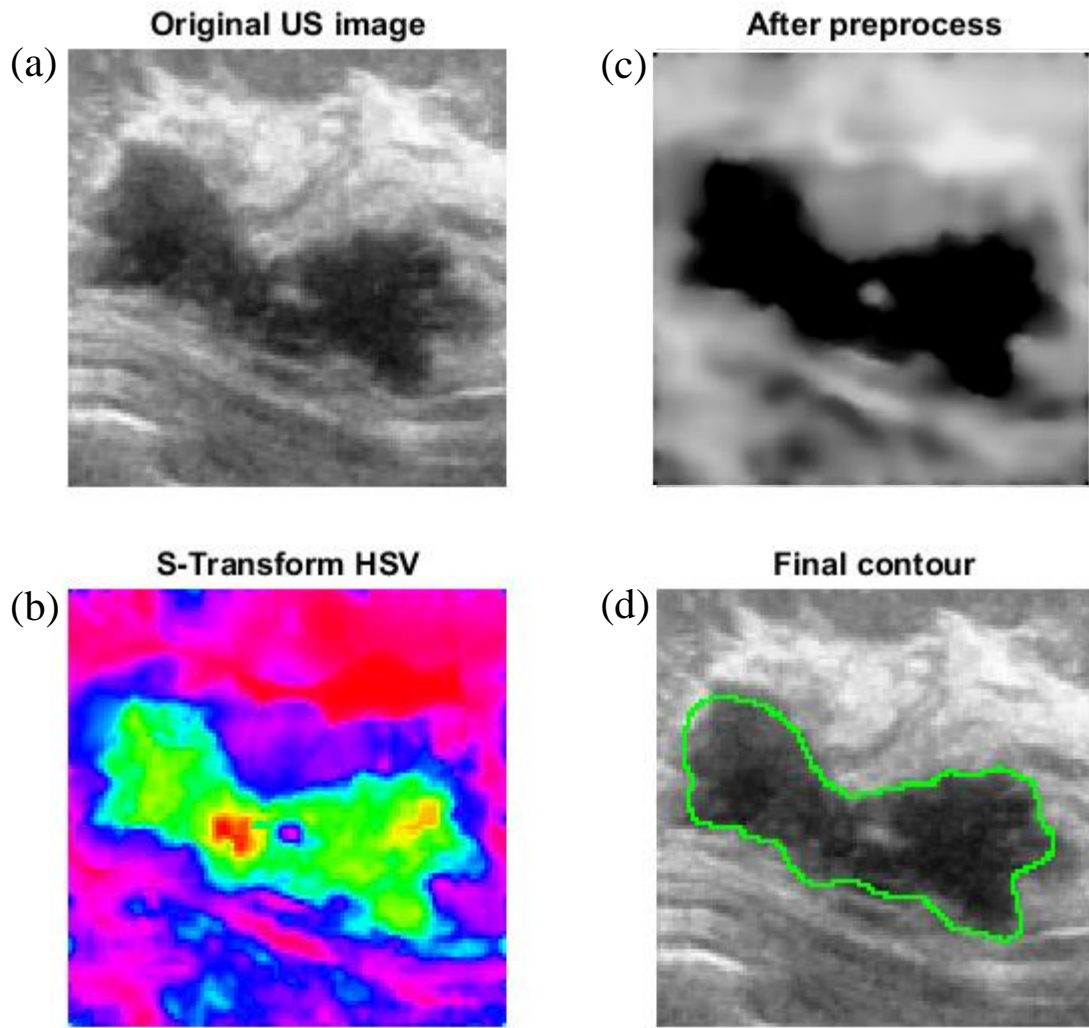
Segmentation of malignant ultrasound breast image.
